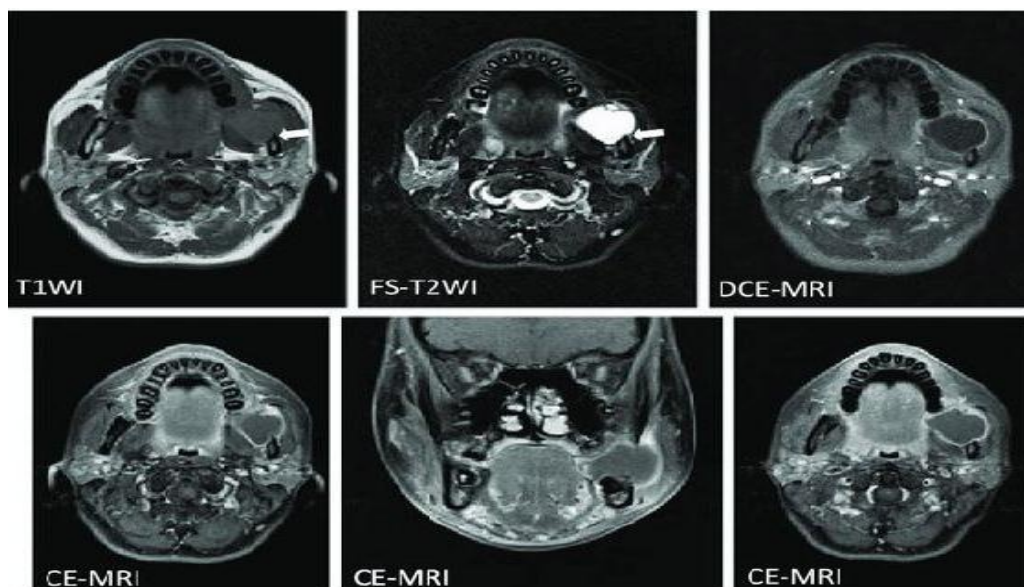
MRI of ameloblastoma. (Wakoh M et al, 2020)
